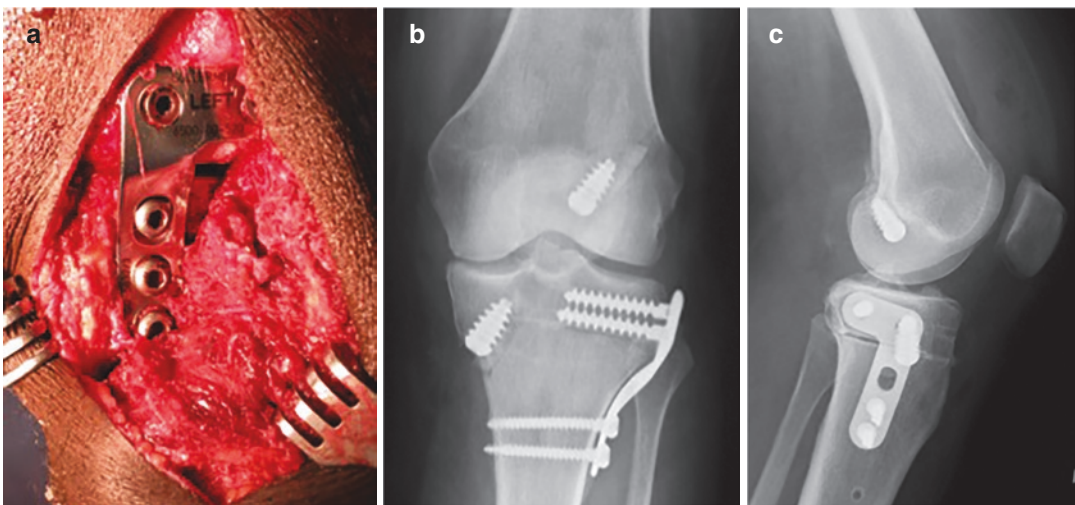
Closing wedge HTO and revision ACL reconstruction. (a) Closing wedge HTO with L-shaped plate. (b) AP x-ray showing final construct with hardware in place. (c) Lateral x-ray
